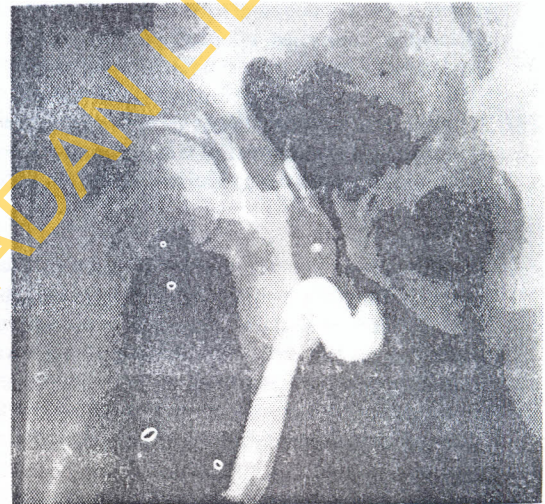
Radiograph of a pre-operative retrograde urethrogram done 3 days after presentation in a patient who was admitted with acute urinary retention and blood at the meatus following a road traffic accident. The study shows abrupt cessation of contrast flow in a posterior urethra with intravasation of the contrast into the pelvic vessels in keeping with a traumatic posterior urethral disruption. Note bilateral fractures of the superior and inferior pubic rami
